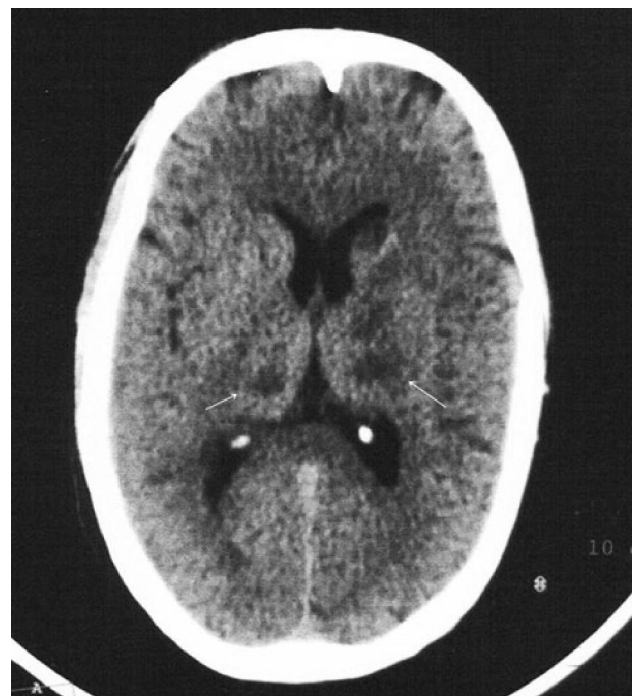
Axial CT scan Brain shows small non enhancing hypodense lesions in bilateral thalamic regions.
